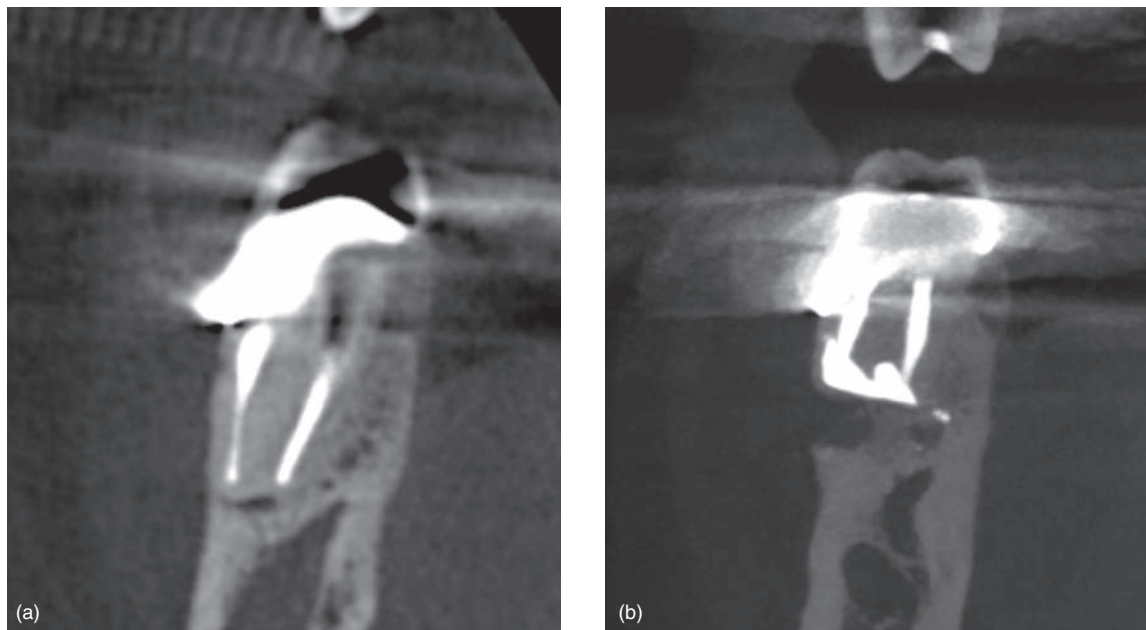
CBCT analysis of endodontic microsurgery on a first right mandibular molar, mesial root. (a) Preoperative coronal view; note the prominent buccal position but absence of fenestration. (b) A 1 year follow-up coronal view. Note the complete cover of the resected root surface by newly formed bone, but the low density area is inferior to the layer of bone and does not show bone reformation. This is limited healing according to PENN 3D Criteria.
